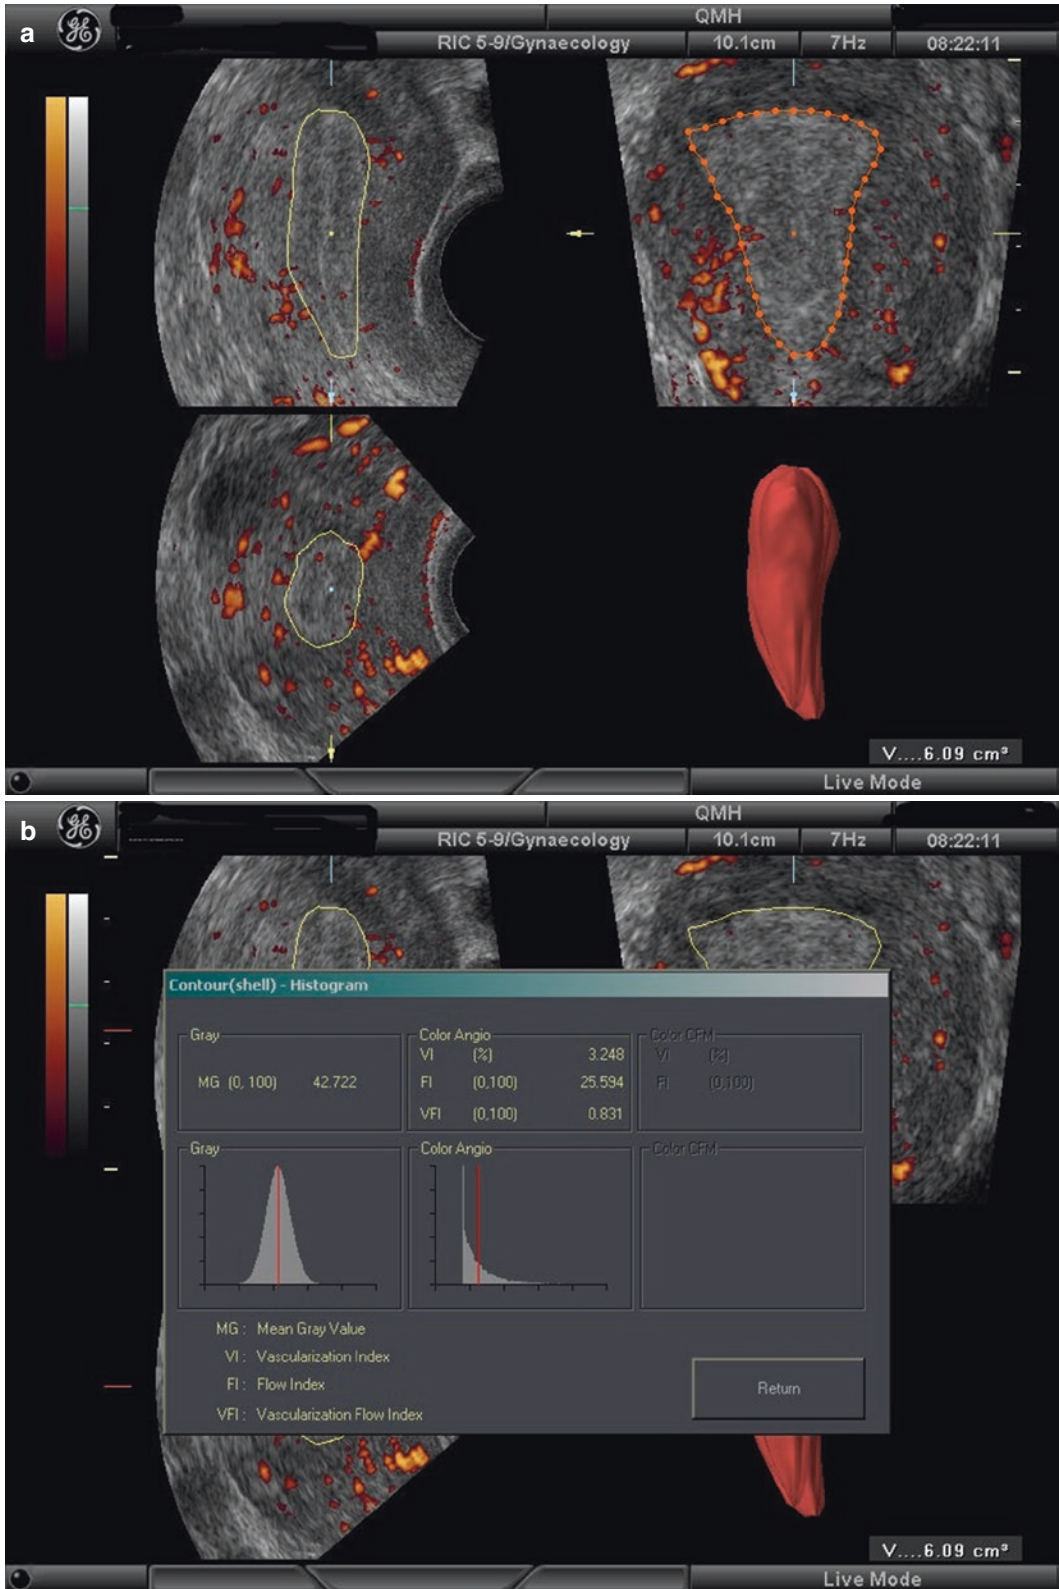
(a, b) Endometrial volume and blood flow measured by 3D Doppler ultrasound
